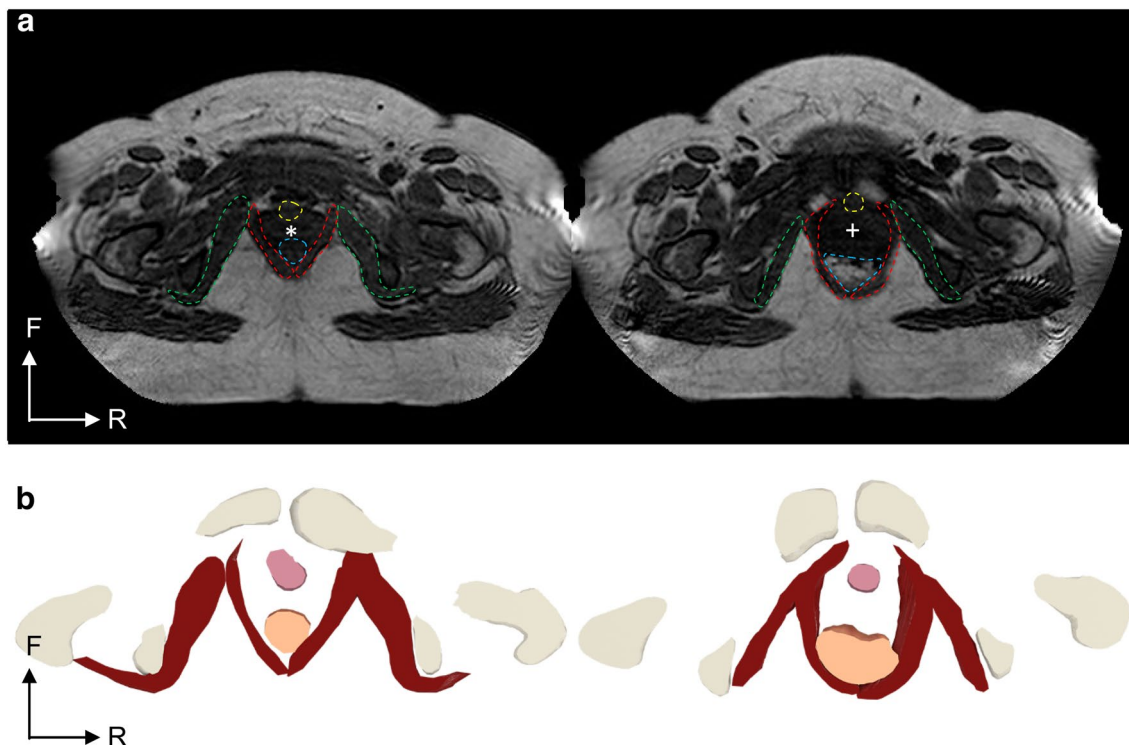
a MRI axial slices of the UGS before (left) and during (right) the second stage of labor. The urethra (yellow dashed line) is brought forward during the descent of the fetal head (+) through the vagina (*). The vagina is no longer visible during the expansion of the perineum. The anterior fascial insertions of iliococcygeal muscles (red dashed lines) on obturator internus muscles (green dashed lines) are pushed sideways. Obturator internus muscles are thickening, principally along their anterior portion. The rectum (α) is pushed backward
